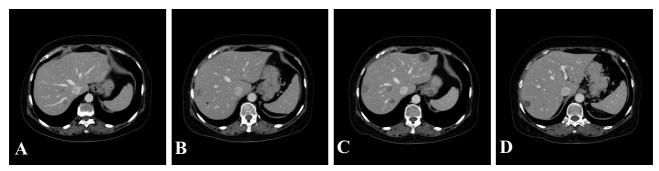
CT findings of liver metastases. A, B) The period after pazopanib was administered. C, D) The period after IAP chemotherapy was completed. Multiple liver metastases have grown.
